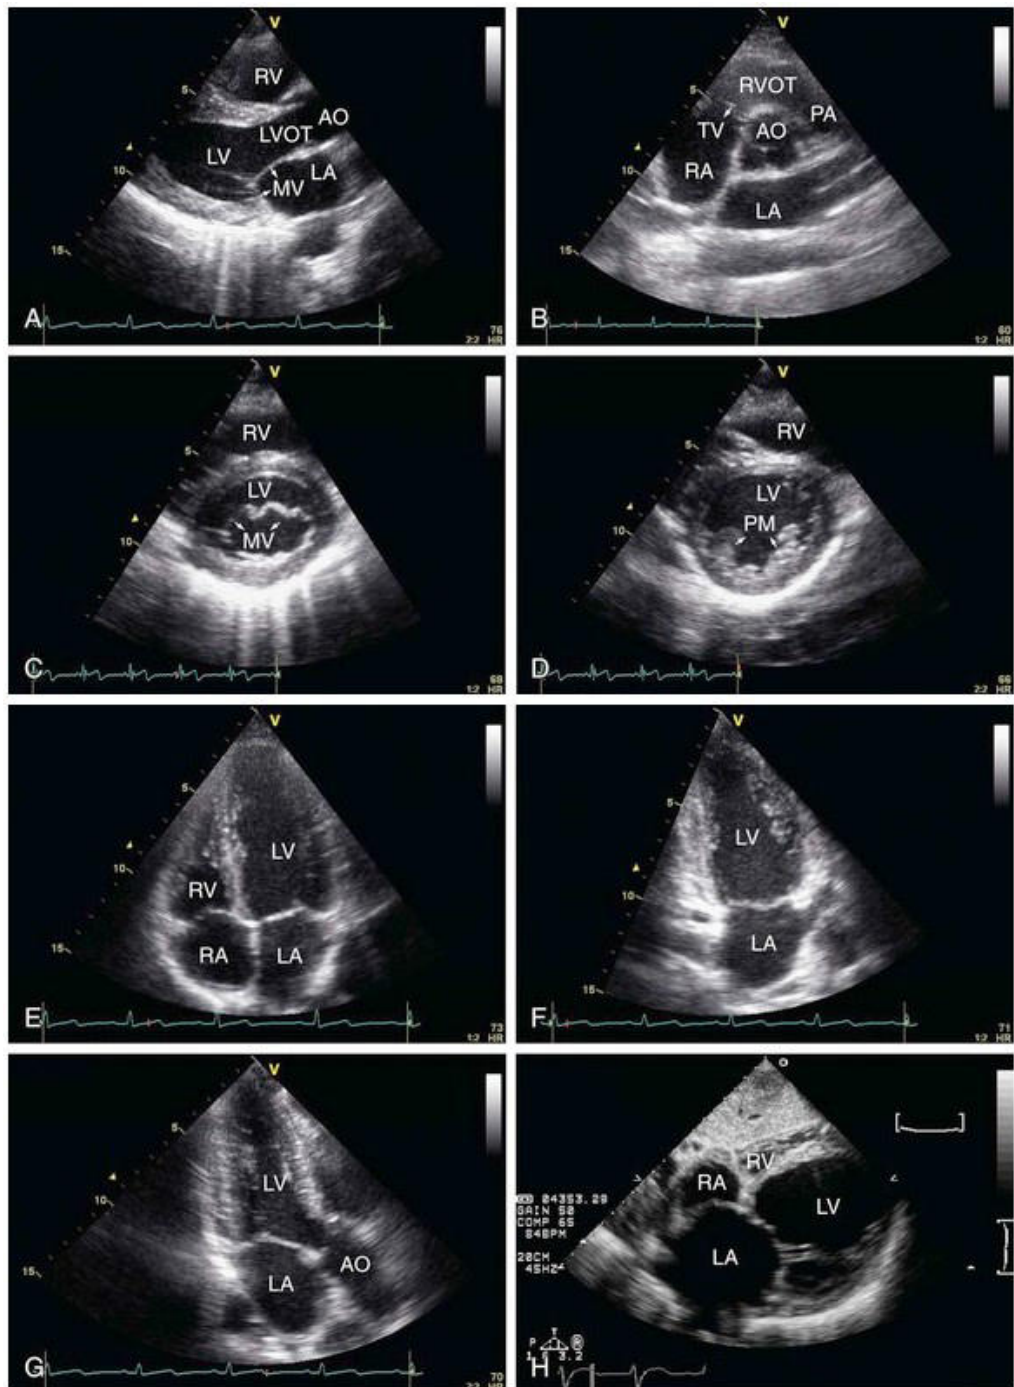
Views for transthoracic echocardiography: A through D: Images from the parasternal position. A: long axis view. B: short axis view. C: short axis view of basal left ventricle with the mitral valve open. D: short axis view of left ventricle. E, F, and G: images from the apex. E: apical four-chamber view. F: two-chamber view. G: three-chamber view. H: subcostal view. The chambers and structures highlighted are the following: AO, aorta; ASC Ao, ascending aorta; DESC Ao, descending aorta; LV, left ventricle; LVOT, LV outflow tract; MV, mitral valve; PA, pulmonary artery; PM, papillary muscles; RV, right ventricle; RVOT, RV outflow tract; TV, tricuspid valve. From <https://radiologykey.com/echocardiography-3/>
